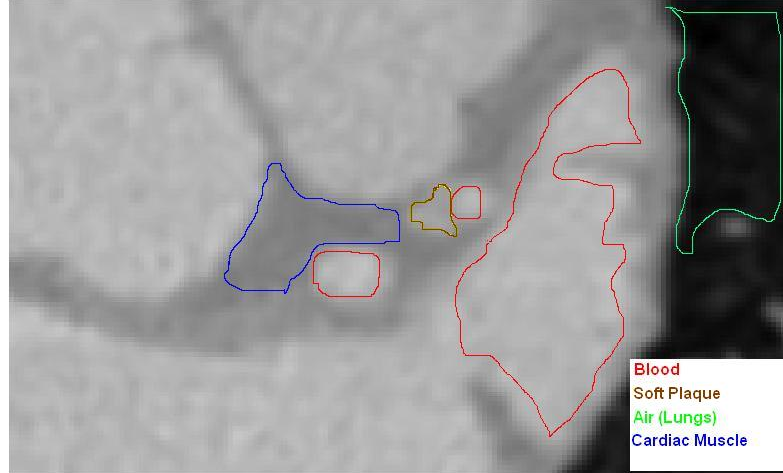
Intensity of Soft Plaque in CTA imaging
